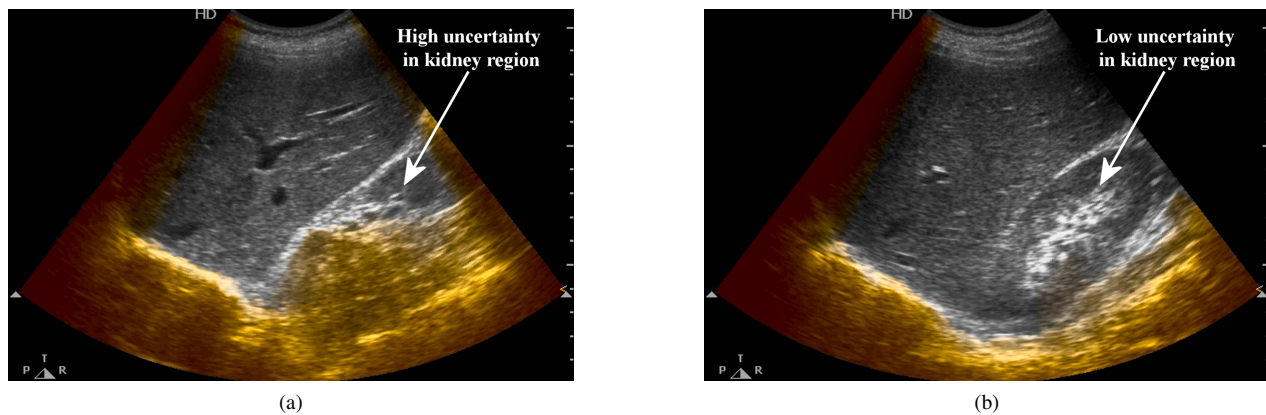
Kidney ultrasound using the liver as acoustic window with applied uncertainty visualization using chroma as visual variables (cf. Section 3.3). A slight repositioning of the transducer results in a considerable increase of confidence in image (b) compared to (a).
